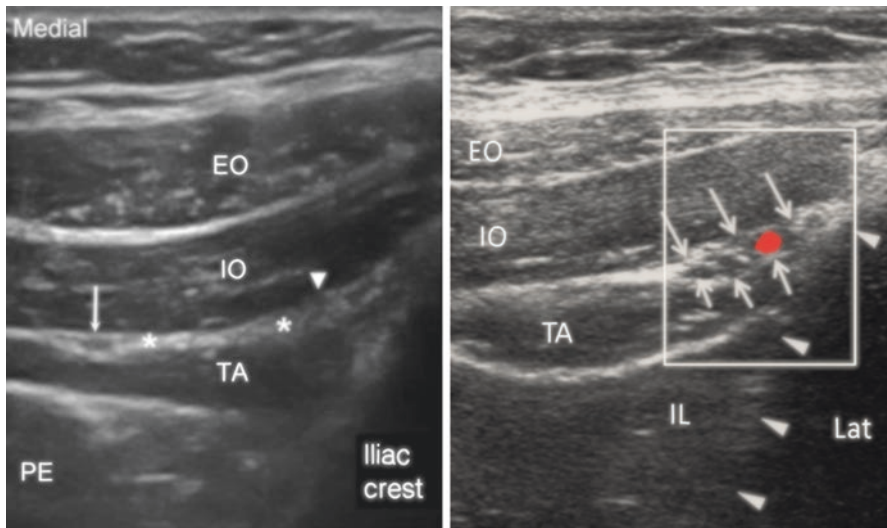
Sonography of the abdominal muscles and ilioinguinal and iliohypogastric nerves. Fascia expansion (arrowhead) indicated where the ilioinguinal and iliohypogastric nerves are (*). The right sonography showed the Doppler scan. The deep circumflex femoral artery is shown with the fascial expansion (arrows) between the IO and TA. Arrow indicated the subcostal nerve. EO external oblique, IO internal oblique, TA transversus abdominis, PE peritoneum. (Reprinted with permission from Philip Peng Educational Series)
